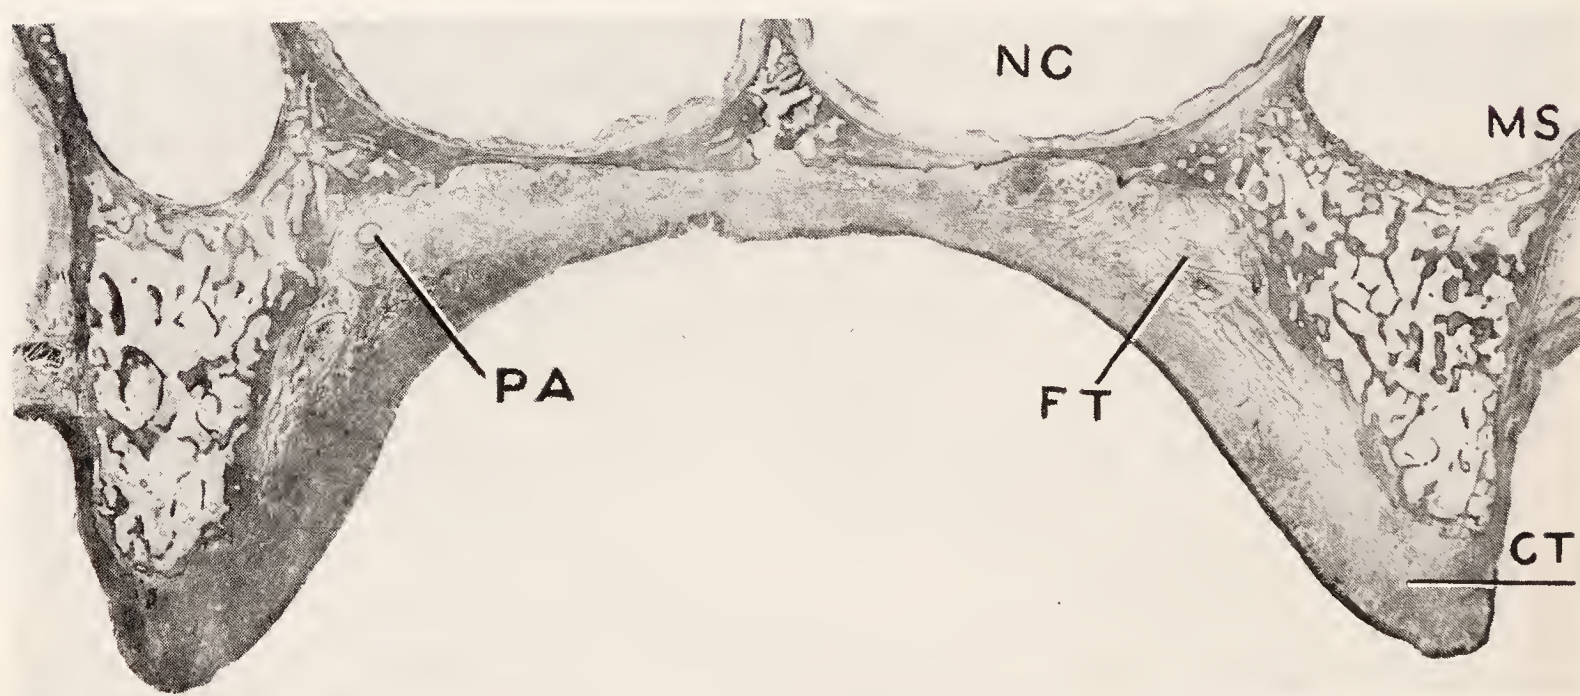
Bucco-lingual section through an edentulous maxilla in the region of the upper first molar. NC, nasal cavity; MS, maxillary sinus; CT, fibrous connective tissue on crest of ridge; FT, fat tissue of palate; PA, palatine artery.
